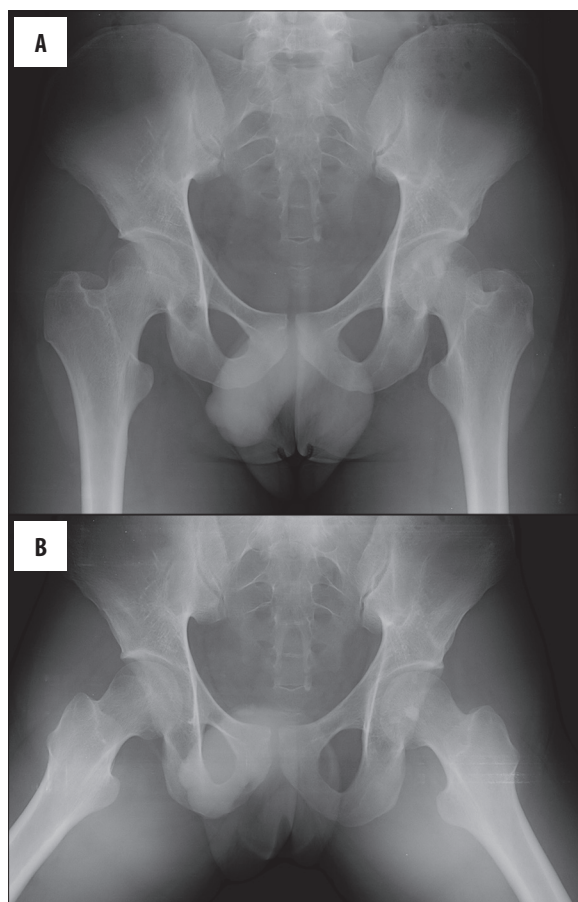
Plain radiographs of the hips in AP (A) and frog-leg lateral (B) projections. There is a valgus deformity of the hips. Apart from that, the hips are unremarkable.
